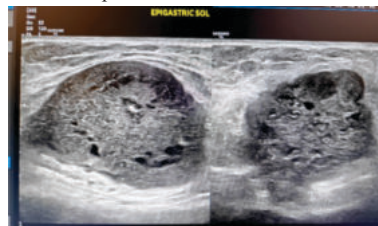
High resolution Ultrasound of the herniated lesion (linear probe) arising from the left liver lobe, showing irregular borders, hypoechoic heterogeneous echogenicity with few cystic spaces representing necrosis.
